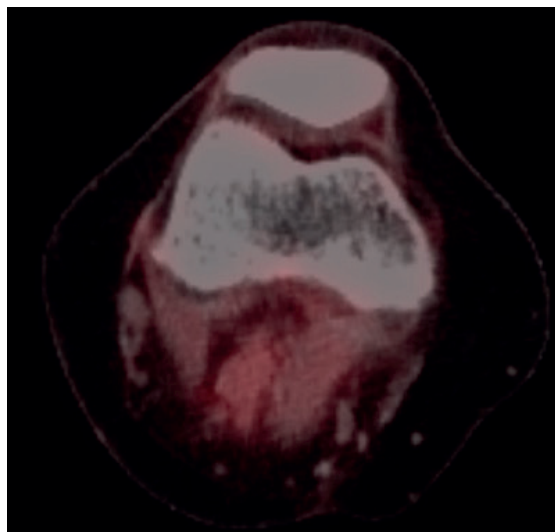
Axial slice of positron emission tomography computed tomography scan 3 months post-treatment showing treatment response and reduction in standardised uptake value of the right popliteal fossa node.
